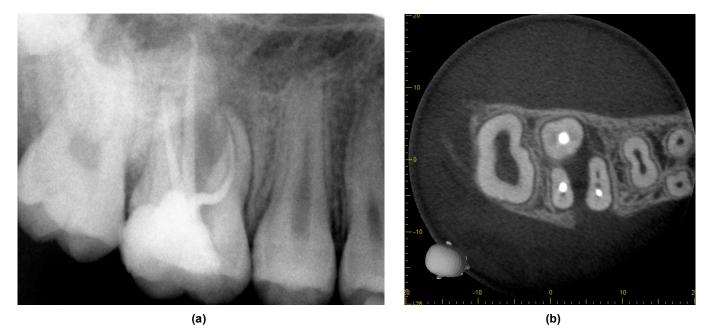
(a): PR of maxillary first molar tooth. (b); CBCT of maxillary first molar tooth - untreated second mesiobuccal canal and excessive bone lose.
